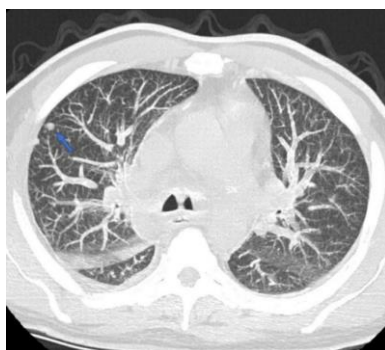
Axial section of a parenchymal windowed chest CT with MIP reconstruction, showing subpleural nodules of the ventral segment of the LSD
